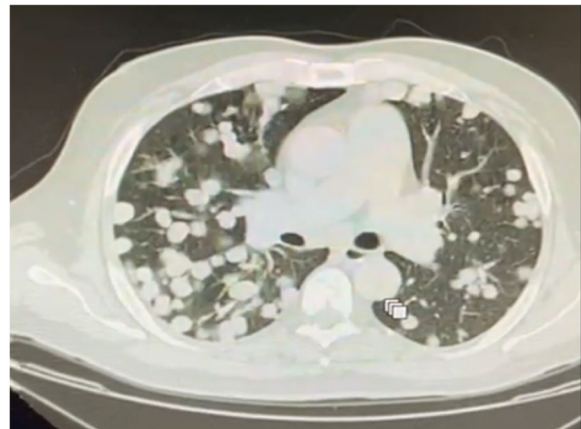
Chest CT (lung window) revealing multiple bilateral, well-circumscribed pulmonary nodules (8-11 mm). These are 'cannonball' in appearance
